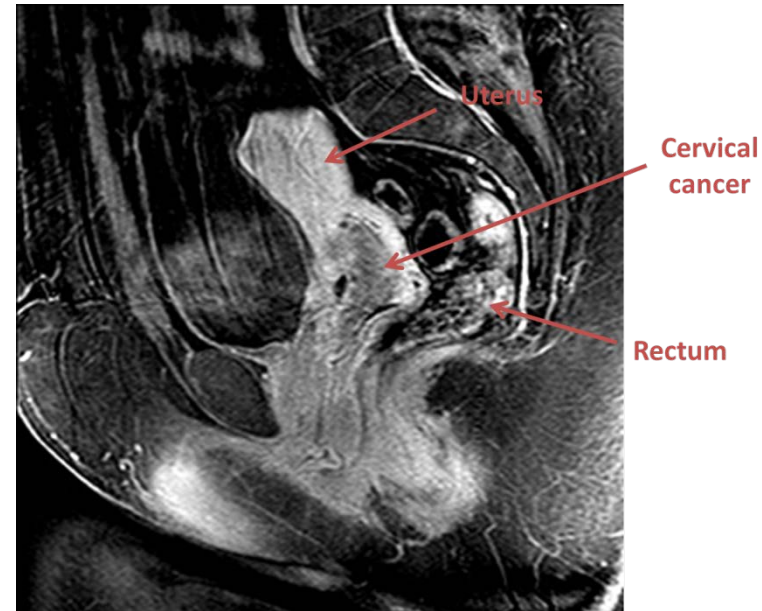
Sagittal contrast MRI. University of Massachusetts Medical School, Department of Radiology.
